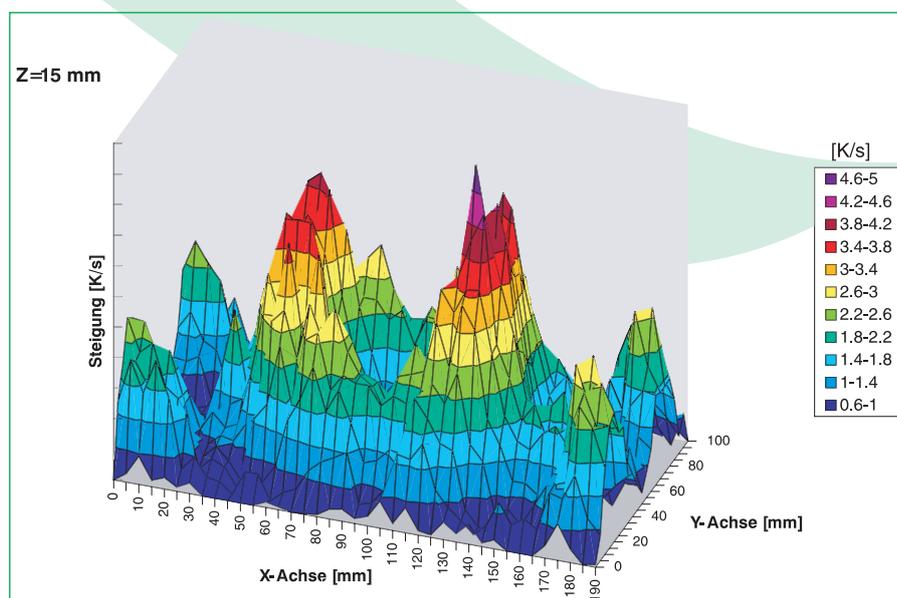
Field distribution and intensities of the cavitation field in one level of a commercially available ultrasonic basin, photographed with thermistor probe
